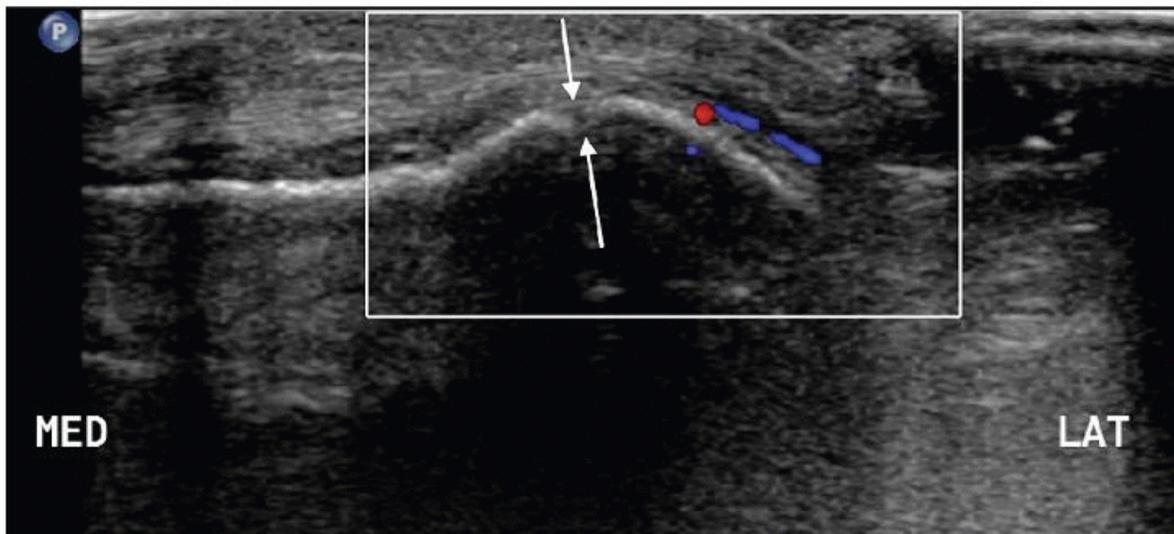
Transverse ultrasound image of the patella demonstrating a bipartite patella (arrows).
